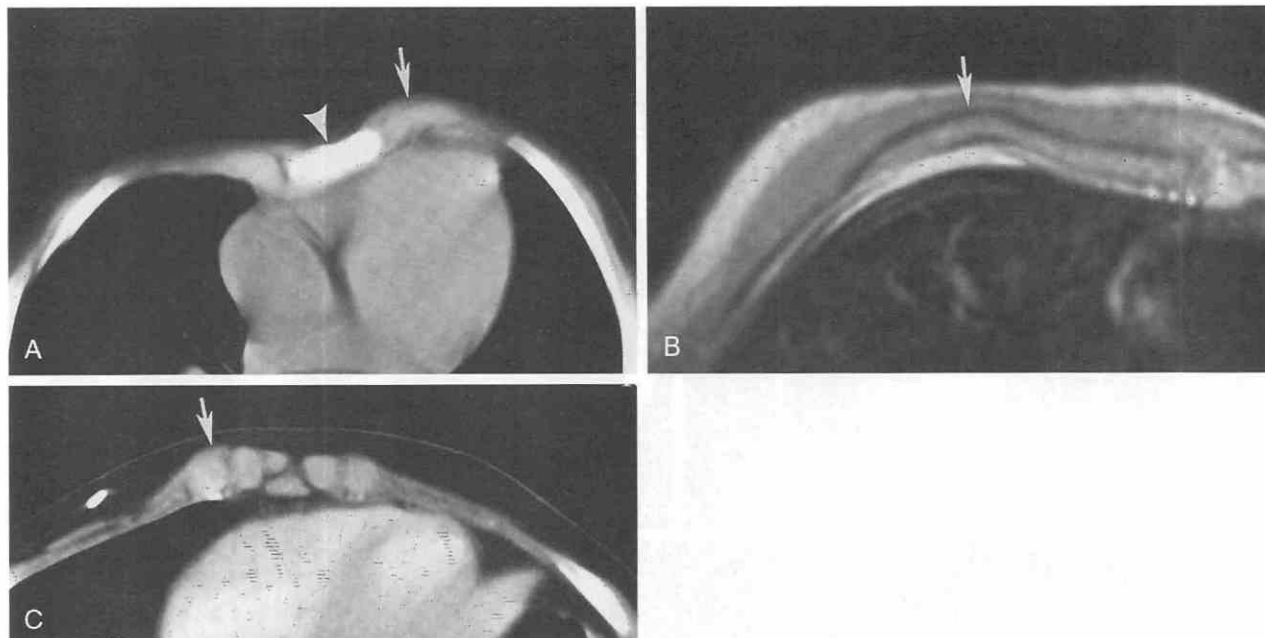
Normal variation of the anterior chest wall, which may present as palpable, nontender lumps on physical examination and be referred for cross-sectional imaging to exclude a mass. *A*, Tilted sternum (*arrowhead*) with associated asymmetrical anterior convex left rib (*arrow*) is shown in a 5-year-old girl. *B*, Anterior convex rib (*arrow*) is shown on T1-weighted image (TR, 740; TE, 15) of a 7-year-old boy. *C*, Asymmetry size of right costal cartilage (*arrow*) is shown on CT scan of a 13-year-old boy. (From Donnelly LF, Frush DP: Abnormalities of the chest wall in pediatric patients. *AJR Am J Roentgenol* 173:1595–1601, 1999.)
